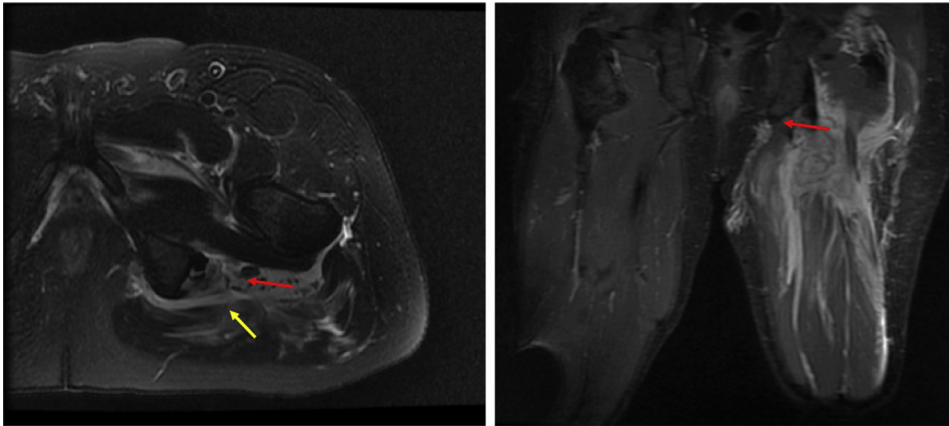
Axial and coronal T2 MRI sequences with fat saturation demonstrating a left-sided Type 2c injury. Type 2c constitutes a conjoint tendon tear with more than 2 centimeters of retraction. Yellow arrow on the axial cut indicates a bare footprint at the ischial tuberosity, and a red arrow indicates an intact semimembranosus origin.
